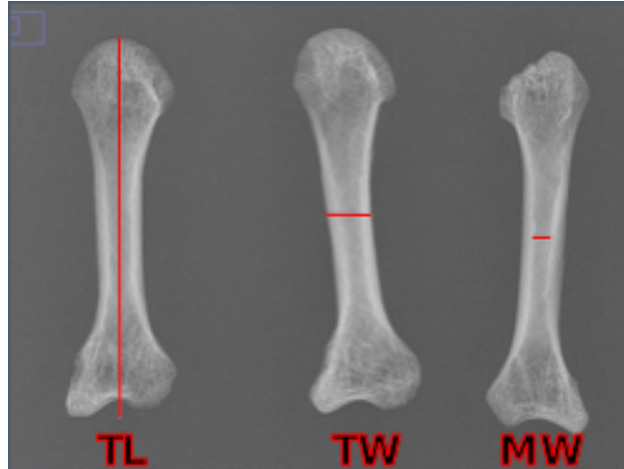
Examples of how total length (TL), total width (TW), and medullary width (MW) are measured on radiographs of second metacarpals from the Tibanica sample.
